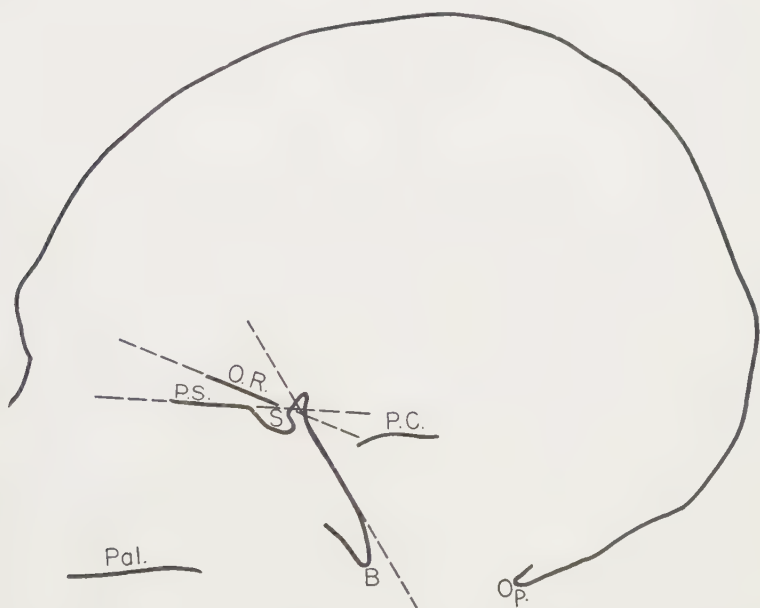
Tracing of a roentgenogram of a normal, non-deformed American Indian skull. (B) basion; (Op) opisthion; (Pal) plane of the hard palate; (P.C.) petrous crest of the temporal bone; (S) Sella Turcica; (O.R.) orbital roof, lesser wing of the sphenoid bone; (P.S.) planum sphenoidale. The method of determining the orbital and planum angles is indicated in the figure.
